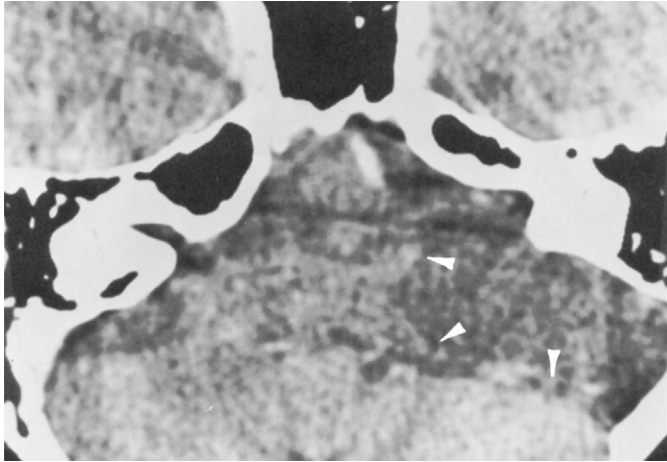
Arachnoid cyst. Computed tomography with contrast. Cerebrospinal fluid density lesion shows mass effect by pushing the cerebellum and brain stem (*arrowheads*). (From Lo WWM: The temporal bone. In: Som PM, Bergeron RT, editors. Head and Neck Imaging, edition 2. Mosby-Yearbook; 1991; with permission.)
